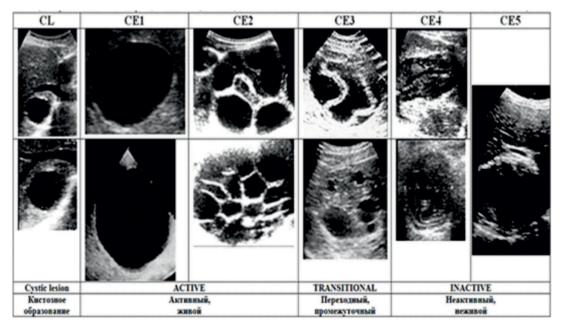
Classification of ultrasound images of echinococcal cysts WHO 2003
